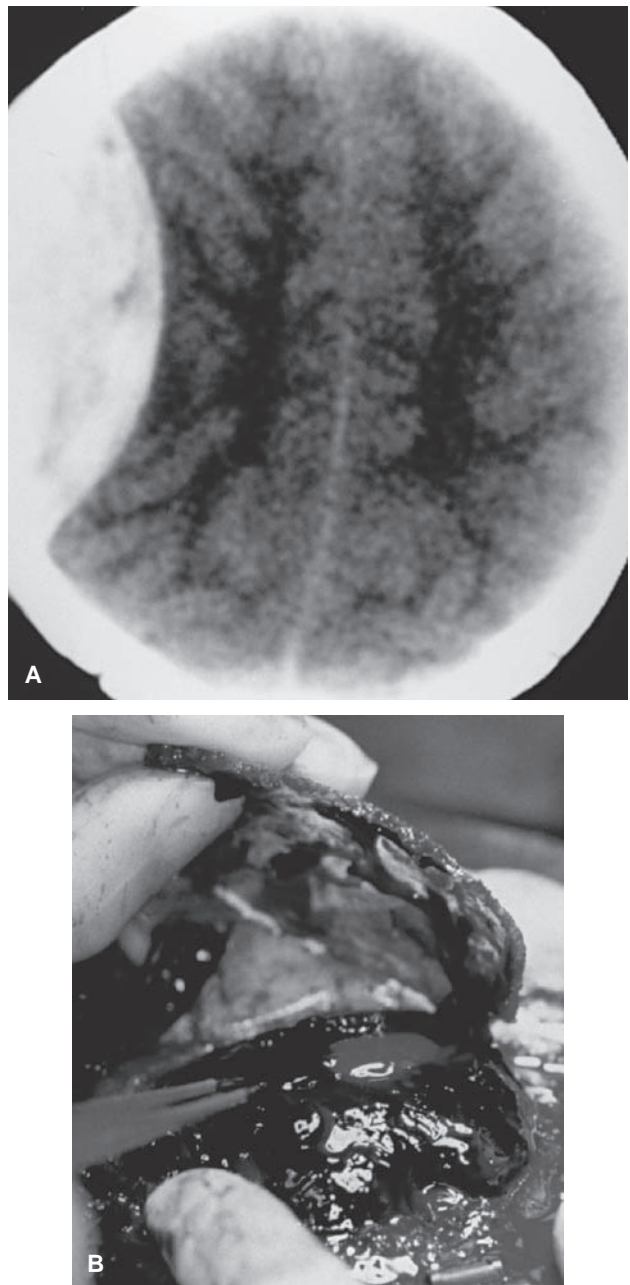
Epidural hematoma (EDH). This 8-year-old boy presented after a sledding accident. He had no loss of consciousness, but he complained of headache and vomiting. A head computed tomographic scan (A) shows the classic biconvex hyperdensity of an EDH. He proceeded to the operating room, where a large mass of clotted blood (B) was removed.
